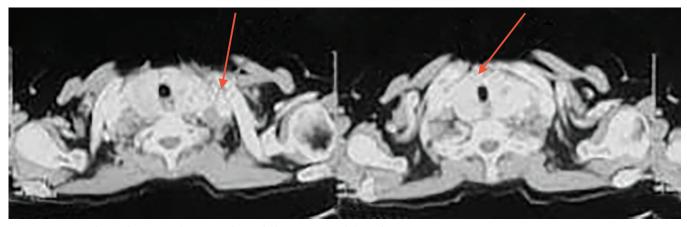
Contrast-enhanced computed tomography neck showing normal thyroid
